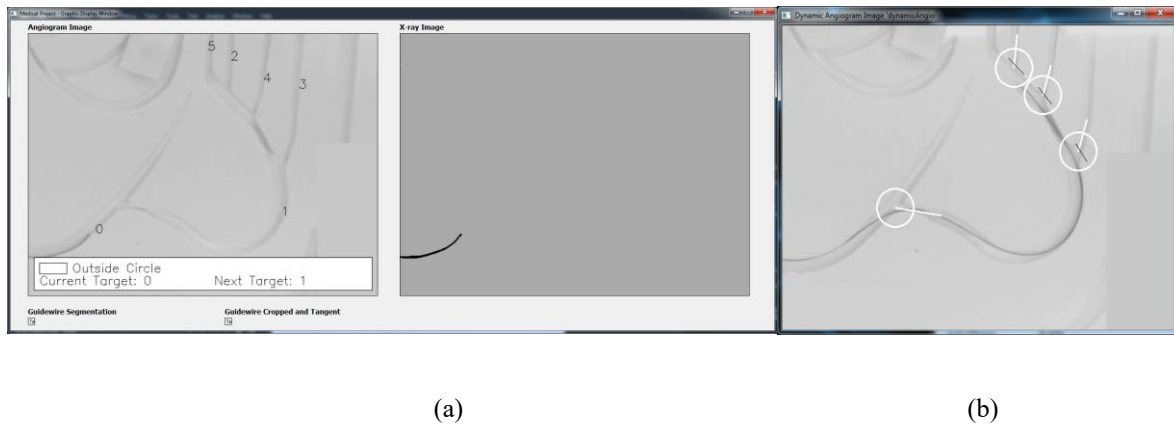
(a) Child window with static angiogram and live x-ray images, (b) Virtual fixtures on angiogram
